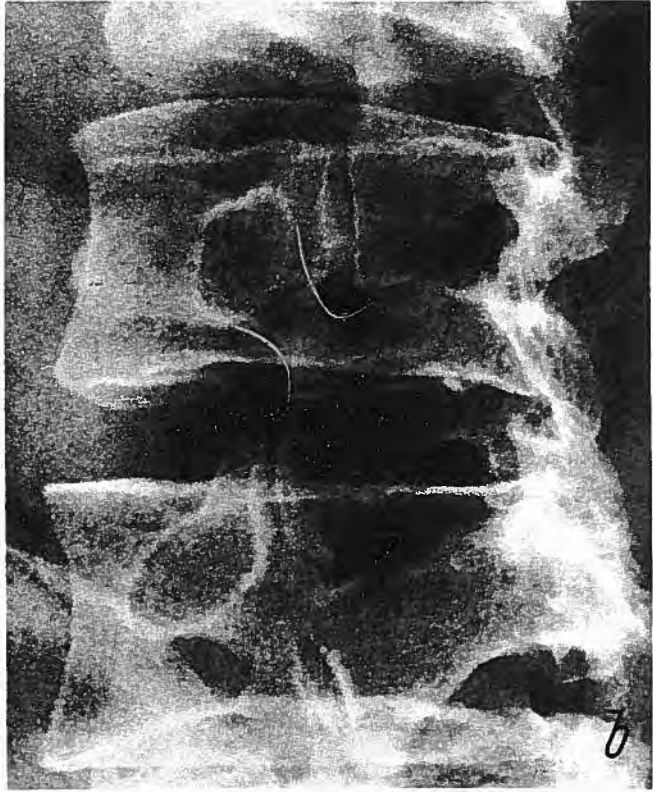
a A lateral radiograph of the lower lumbar spine showing a spondylolytic defect in the lamina of L5. b Normal discograms at L3/4, L4/5 and L5/S1 in this case
